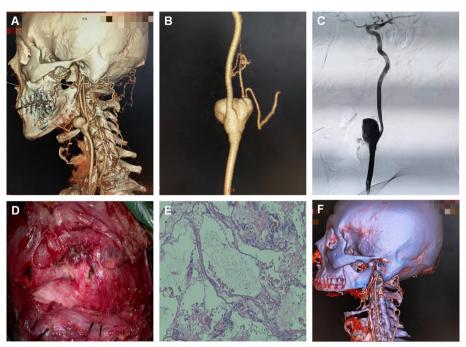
Typical case 3; A 40-year-old man who smokes one pack per day presented with a neck mass and low-grade fever that had persisted for a month. Upon examination, the patient was found to be neurologically intact. A CTA examination was conducted, which revealed an unruptured aneurysm in the left ECCA (A-B). Further investigation through a cerebral angiogram revealed a large aneurysm (19.0 mm in maximum diameter) on the extracranial internal carotid artery (C). After an incisional neck biopsy and pathological examination, it was determined that the patient had an infected aneurysm (D-E). Anti-infection treatment was then administered, and a CTA re-examination was conducted one month later. The results showed that the aneurysm had disappeared and the parent artery had become thinner (F)
